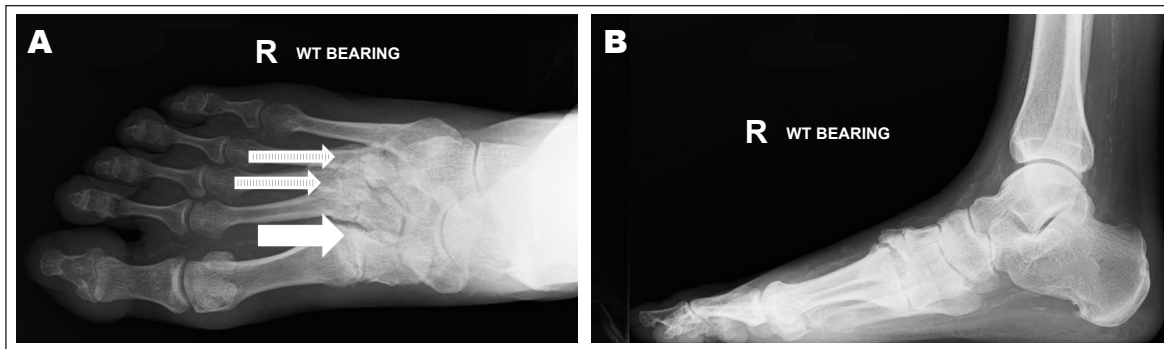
Right foot anteroposterior (A) and lateral (B) radiographs demonstrating erosive arthropathic changes of the tarsometatarsal joints, particularly the first. Joint space is reduced and sclerosis is present (solid arrow). In addition, there are ununited fractures at the base of the third and fourth metatarsals (striped arrows).
